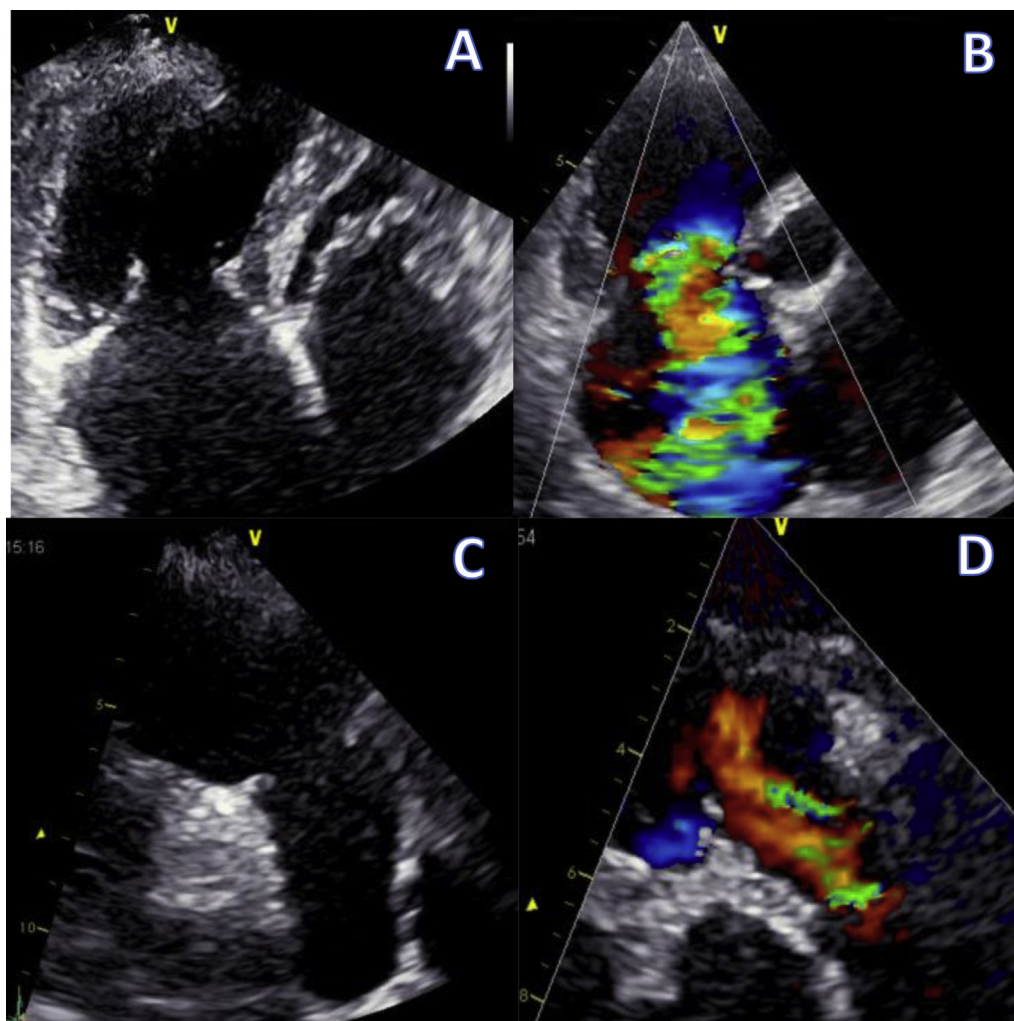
A, C. 2D views of the tricuspid and pulmonary valves. Fixation of both valves in an almost opened position with impressive leaflet shortening in the pulmonary valve. B, D. Same views with color Doppler displaying severe regurgitation through both valves.
